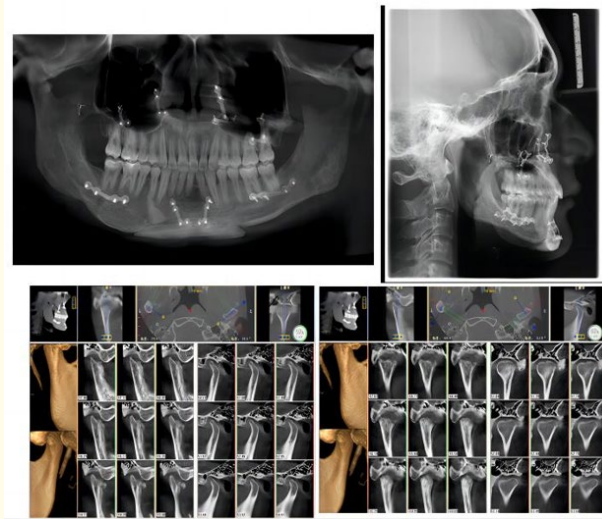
X-ray examination after operation.
